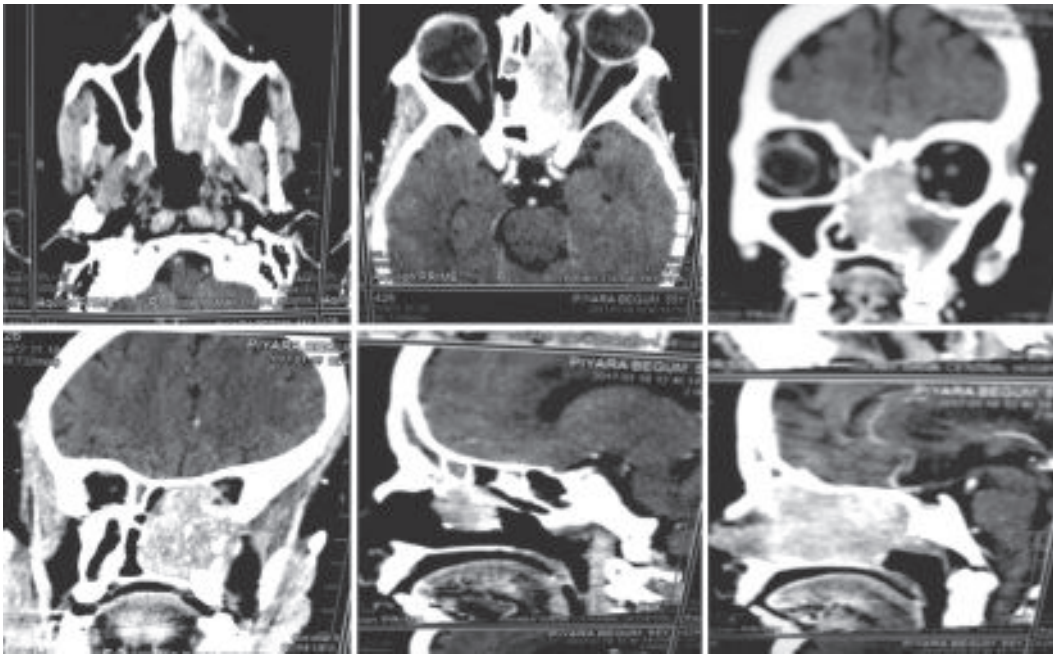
CT Scan Axial, Coronal and Sagittal section]
